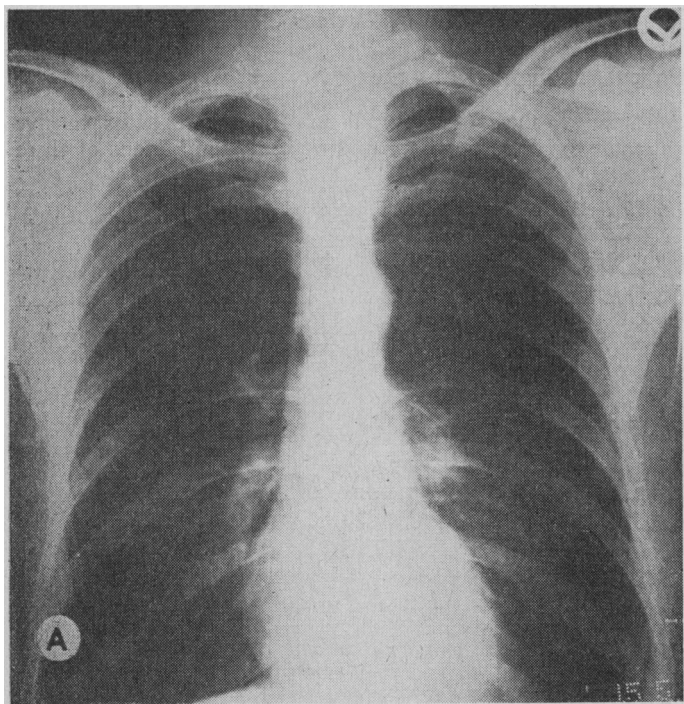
Case 12. Chest radiograph (A) before operation, showing bilateral apical bullae, and (B) three months after the second stage of resection of the bullae, showing new bulla at right base.
